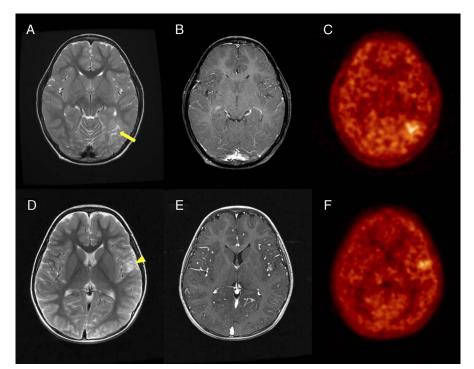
Different shape of MET uptake in DNETs with increased proliferative activity. MRI and PET images of a 5-year-old girl and a 3-year-old boy. The first patient had an ill-defined T2-hyperintensity lesion with no definite contrast enhancement in the left temporo-occipital lobe (arrow) (A and B). The lesion demonstrated globular-shaped uptake on MET-PET images (C). The patient underwent GTR of the tumor, which exhibited a Ki-67 count of 18.2% in the pathologic examination. The other patient had a T2-hyperintensity lesion with subtle contrast enhancement in the left temporal lobe (arrowhead) (D–E). The lesion demonstrated globular-shaped uptake on MET-PET images (F). The patient underwent GTR of the tumor, which exhibited a Ki-67 count of 26.3%. Both patients were event-free at the last follow-up.
